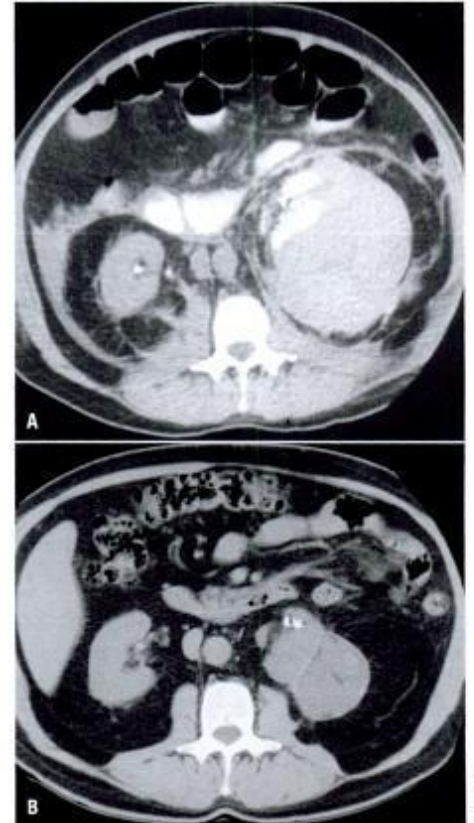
A, Computed tomography (CT) scan of a stone patient 48 hours after left extracorporeal shock wave lithotripsy (ESWL) for a 1 cm non-obstructive stone in the left renal pelvis. The patient received 1,000 shocks at 22 kV with an unmodified HM3 lithotripter. B, Abdominal CT 8 years after ESWL demonstrating persistence of a smaller hematoma around the left kidney.
